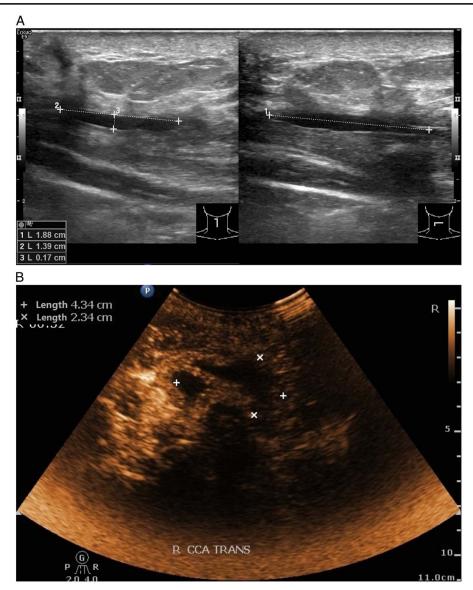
Cervical ultrasound assessment for PNH: A. Initial ultrasound assessment by a junior sonographer showed localized subcutaneous effusion with no evidence of hematoma formation; B. Subsequent contrast-enhanced ultrasound by an experienced senior sonographer demonstrates a compressible, flowable high-echoic region in the retrosternal area, showing no postcontrast enhancement, indicative of no active hemorrhage.
